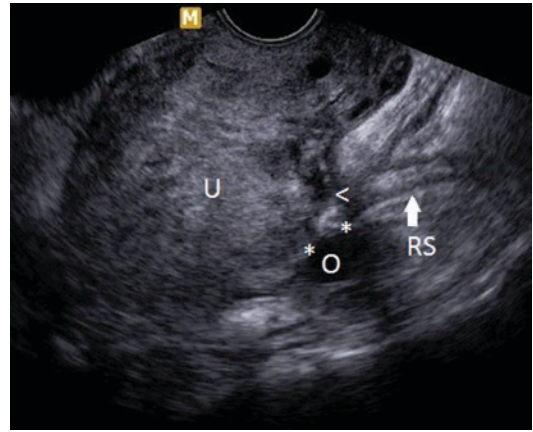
A transvaginal sonography (TVS) image (in the sagittal plane) demonstrating an anteverted, retroflexed uterus (U). The rectosigmoid bowel (RS) is adherent posteriorly to the uterine fundus (indicated by <), causing POD obliteration. The ovary (O) is adherent posteriorly to the uterine fundus and to the rectosigmoid bowel (indicated by asterisk)
